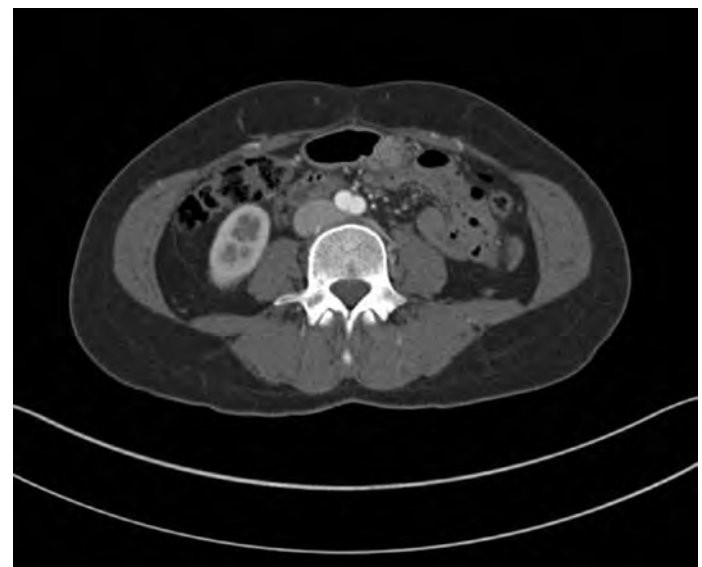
CT angiograms may help to choose the perforator with the best diameter and the least dissection of the muscular segment.
